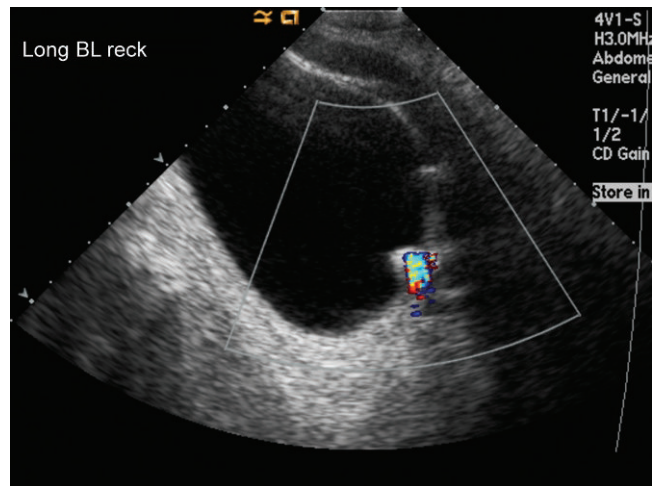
Color Doppler image of the same stone demonstrates "twinkle" artifact posterior to the stone.
